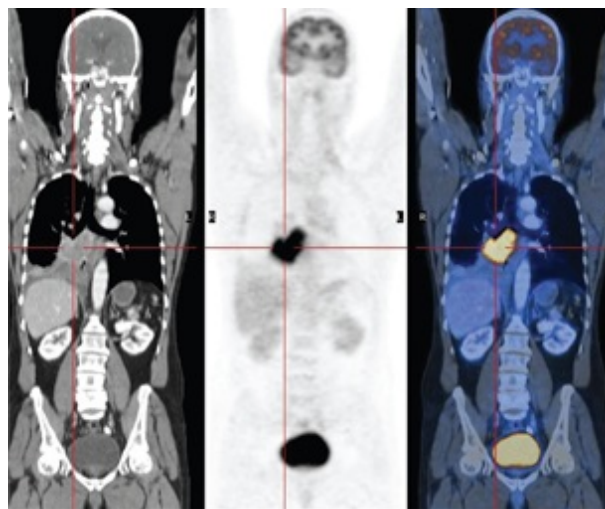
Left: a CT scan showing anatomical details. Middle: a PET scan showing in black zones of high biological activity. Right: the PET scan superimposed on the CT scan, showing the locations of these active zones [36].*
